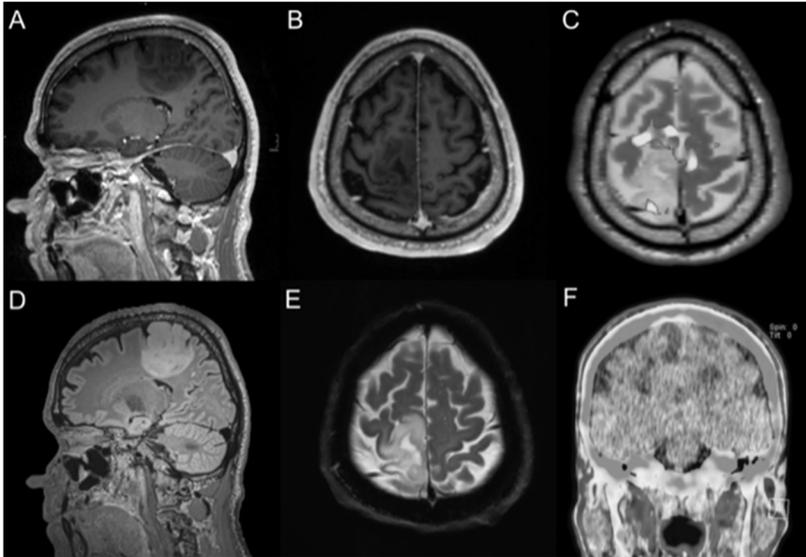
Preoperative investigation of brain tumors with structural MRI, functional MRI and positron emission tomography. (A) Sagittal and (B) axial contrast-enhanced T1-weighted images demonstrate a parietal/postcentral lesion with non-significant contrast-enhancement that is hyperintense on (D) sagittal FLAIR and (E) axial T2-weighted sequences. (C) Functional MRI is able to localize motor function of the lower extremity that is in close proximity to the anterior tumor margin according to T2-weighted images. (F) Positron emission tomography is capable of identifying an intratumoral region (red) of increased tracer uptake that might already be a sign of focal malignant transformation of an initial low-grade glioma.
